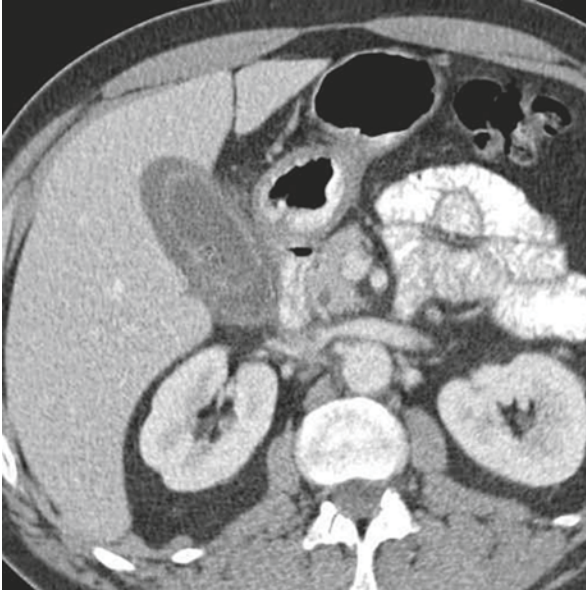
Abdominal CT: acute cholecystitis
